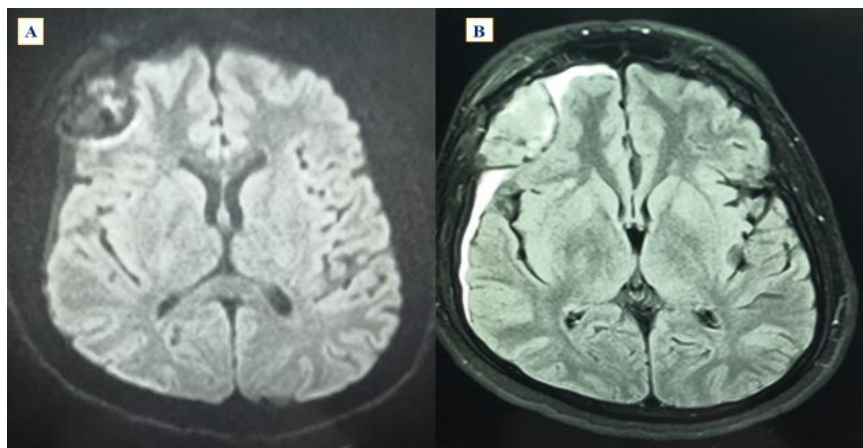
Axial MRI images A and B show a 35-year-old male with an ipsilateral Temporal (SDH) subdural hematoma and a post-traumatic right Frontal (EDH) epidural hematoma.
